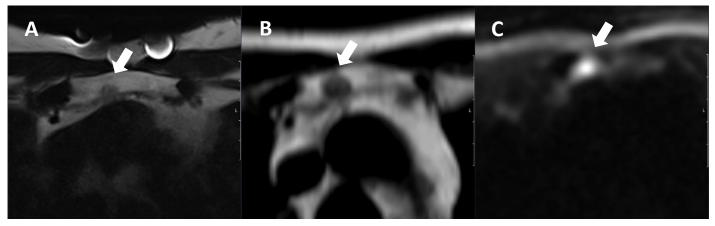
Baseline T2-MRI (A) compared to FU T2-/DW-MRI (B, C) 15 months after SBRT. White arrow shows the BM.
